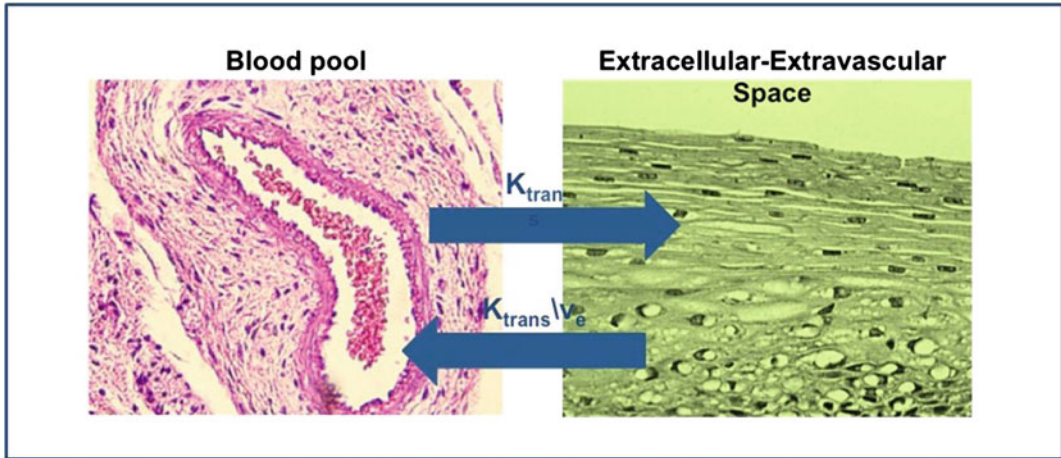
Pharmacokinetic bicompartimental model on the basis of dynamic contrast-enhanced MRI. K_{trans} is the tissue-specific constant that regulates contrast medium
